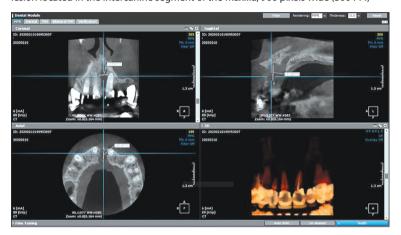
The 3-year follow-up cone-beam computed tomography showing reduced size of the radiolucency; 900 pixels wide (300 PPI)
